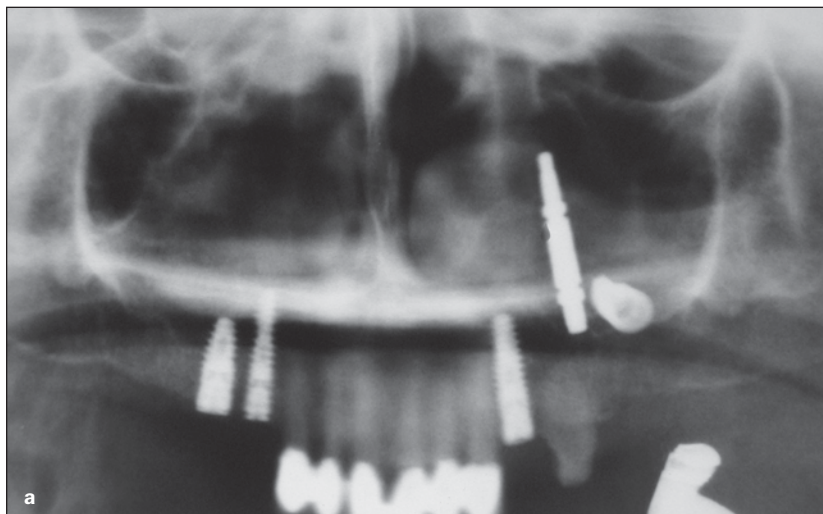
Panoramic radiograph showing the displacement of a dental implant and an implant driver for contra-angle.
